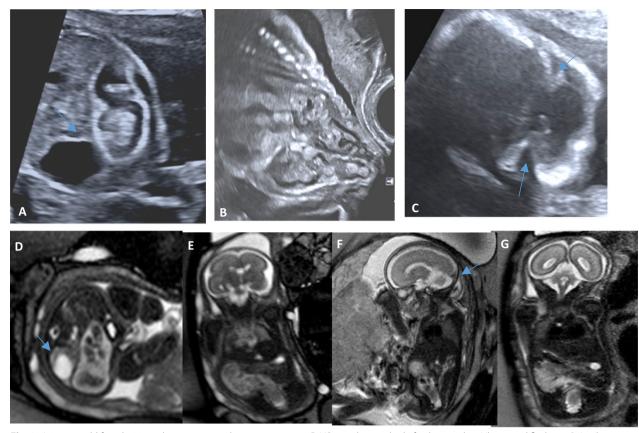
A 34-year-old female 28 weeks pregnant underwent a routine 4D US revealing multiple fetal anomalies. Ultrasound findings: A Axial trans-abdominal image of the fetal pelvis, B sagittal transvaginal image of fetal abdomen and pelvis shows the dilated sigmoid colon and rectum down to the level of the anorectal junction with absent echogenic anal dimple and multiple echogenic intra-luminal well-defined lesions (enterolith). A The image also shows a well-defined cystic structure posterior to the dilated rectum with a thin echogenic wall. C Axial trans-abdominal image of fetal neck revealing subcutaneous cystic lesion in the fetal nape with communication with a bony defect in the occipital bone. Fetal MRI findings: D, E, F, G axial, coronal, sagittal, and coronal T2WIs, respectively, revealed dilated rectum, sigmoid, and descending colon with multiple enteroliths (arrowed) within (low T2 signals oval structures) and detected narrowed rectal segment below the apex of the bladder (low type). D The axial image revealed a low T2 signals of a cystic lesion (arrowed) posterior to the rectum (denoting calcification). G Coronal T2WIs revealed smooth fetal perineum with an absent anal dimple. F The sagittal image revealed the occipital encephalocele likely representing sequel of VACTERL anomaly. IUFD at GA 29 weeks
